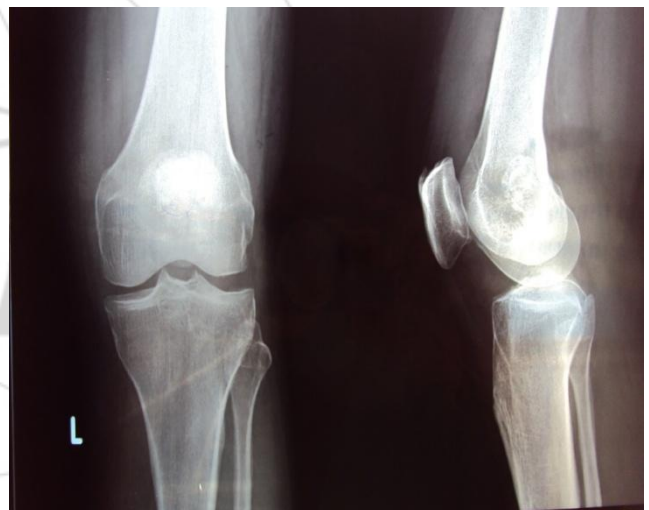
X-RAY- reveals an island of calcification in the distal end of femur
